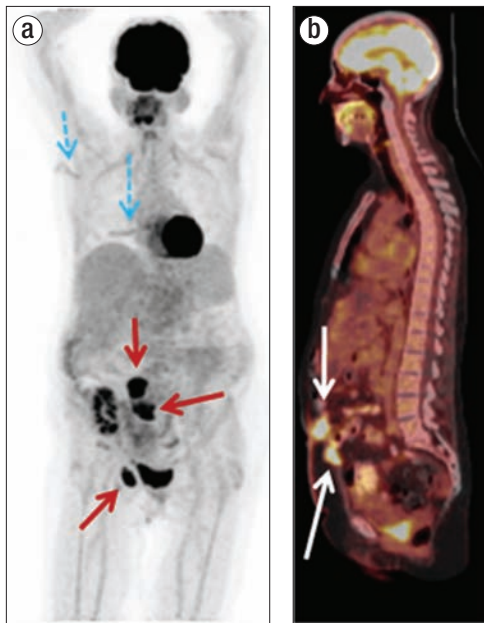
(a) Whole-body MIP image from an F-18 FDG PET/CT demonstrates abnormal radiotracer uptake within the two separate regions of the anterior abdominal wall as well as the right inguinal region (solid red arrows). Linear uptake in the right back and axilla (blue dashed arrows) corresponds to the melanoma excision and axillary node dissection sites. (b) Sagittal whole-body image from the same patient shows abnormal focal radiotracer uptake in two separate areas of the anterior abdominal wall (white arrows). (c) Transaxial CT and (d) FDG-18 PET/CT images at the level of the superiorly located abdominal wall mass show abnormal radiotracer uptake in the midline anterior wall on FDG-18 PET/CT, which corresponds with the anterior abdominal wall mass seen on CT (orange arrow). Also shown in these images are a right renal transplant (curved arrow) and polycystic left kidney (thin arrow).
